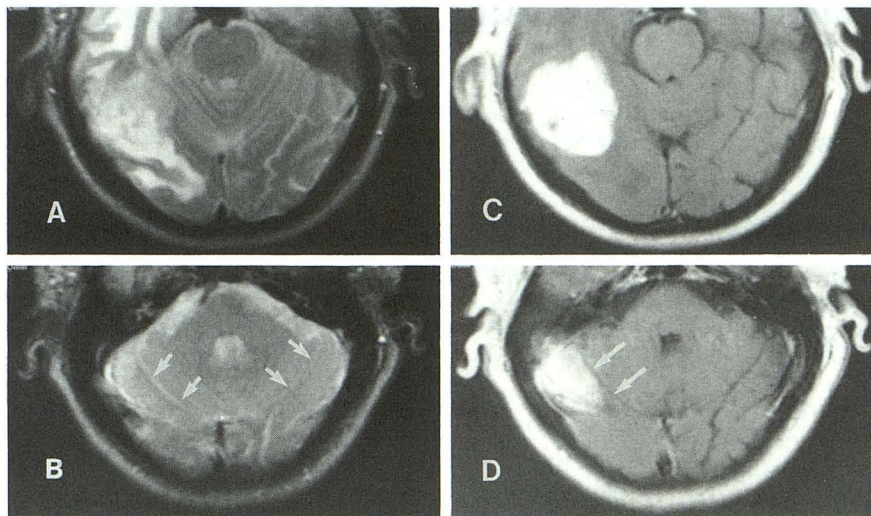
Axial T2-weighted images (2500/100/1) from cranial (A) to caudal (B) show abnormal signal change in the right temporo-parietal region. In retrospect, there is very slight hyperintensity in the right occipital region (arrows) relative to the left.
